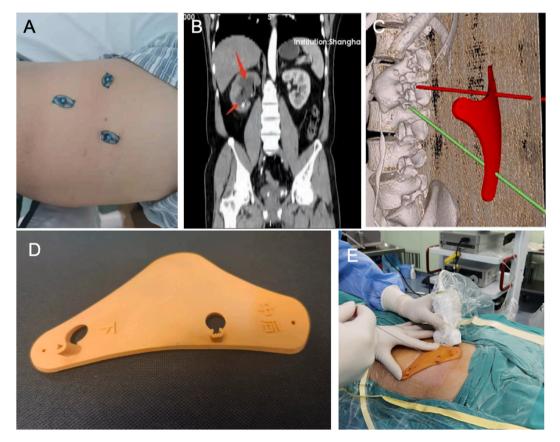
A : 3 signs marked on the skin; B: CT scan of puncture location (Red arrow indicates position); C: Position and angle of the puncture via the navigation template toward the kidney calices; D: The template with penetration point; E: The process of surgery with using the template.
